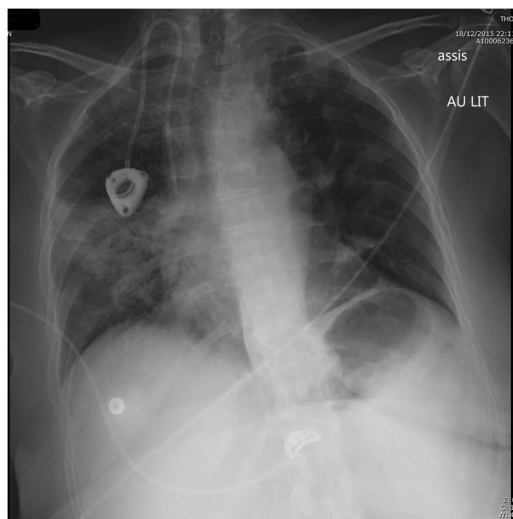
Chest X-rays showing unilateral middle lobe infiltrates mimicking bacterial pneumonia. Note the presence of internal jugular vein implantable chamber for chemotherapy.
